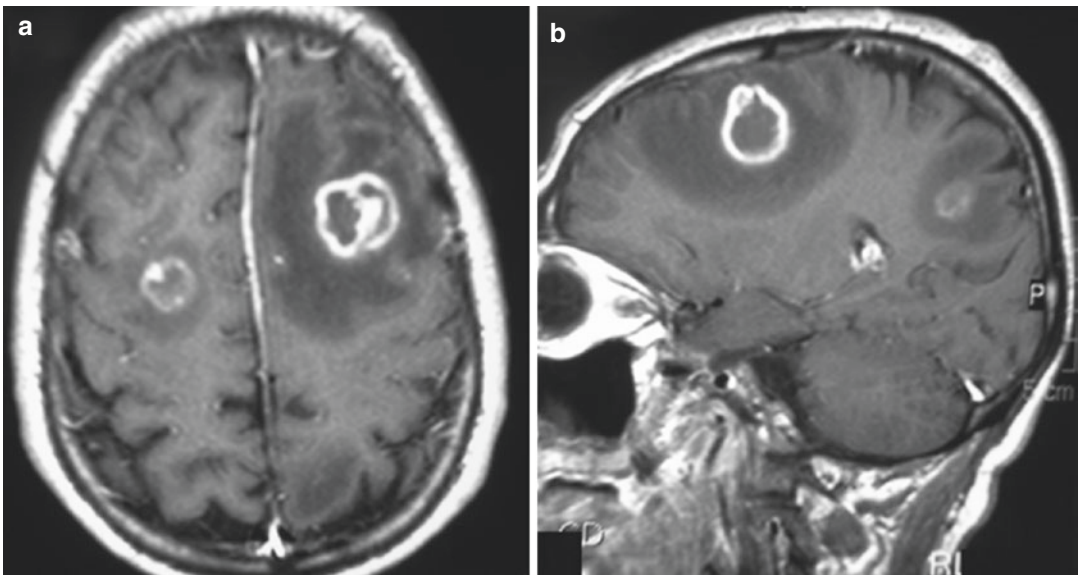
Tuberculous brain abscess (TBA). Axial (a) and sagittal (b) post-contrast T1-weighted MRIs show multiple TBAs as irregular thick ringlike enhancing lesions in both frontal lobes and *left* parietal region with peripheral edema
